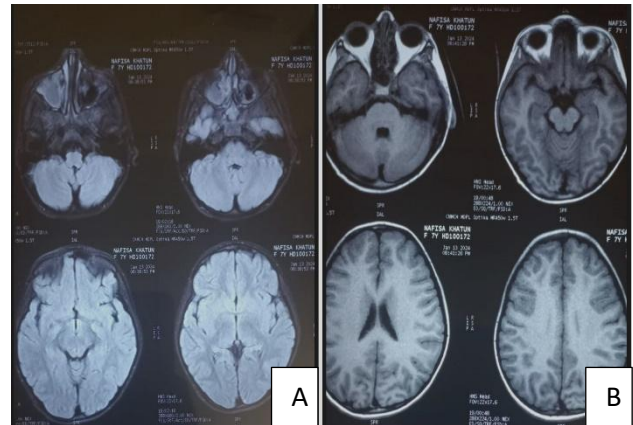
(A and B): MRI brain showing no abnormal changes in the child having opsoclonus; ruling out any possibilities of cerebellitis or demyelination.
